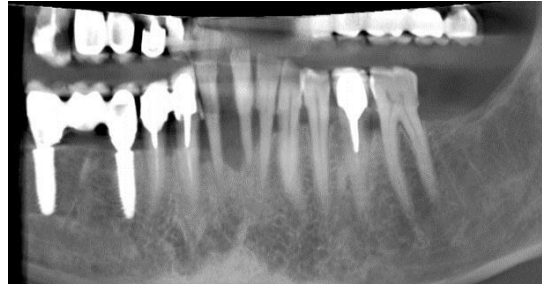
Preoperative CT showing local periodontal lesions on the 24,26 tooth.
